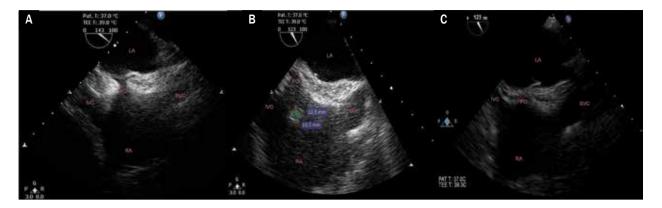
Bicaval view on transesophageal echocardiography: fossa ovalis (FO) (A); preablation (B); postablation (C) at 8-weeks follow-up; IVC – inferior vena cava; SVC – superior vena cava; RA – right atrium; LA – left atrium
